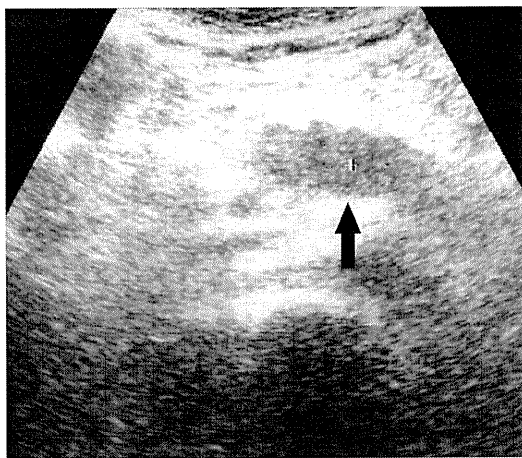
Abdominal ultrasonography (US) of the pancreas. US showed the partially enlarged pancreas body and tail with homogenous hypoechoic pattern (arrow).
